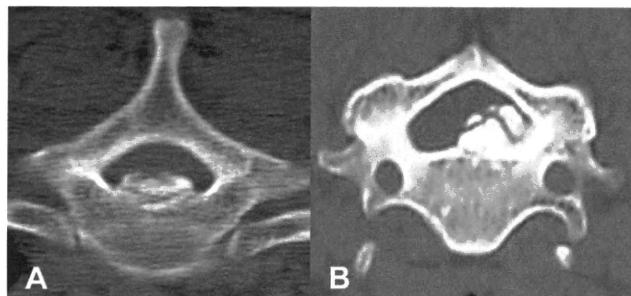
Axial ossified pattern of OPLL on CT or MRI. A, central type; B, lateral deviated type.
